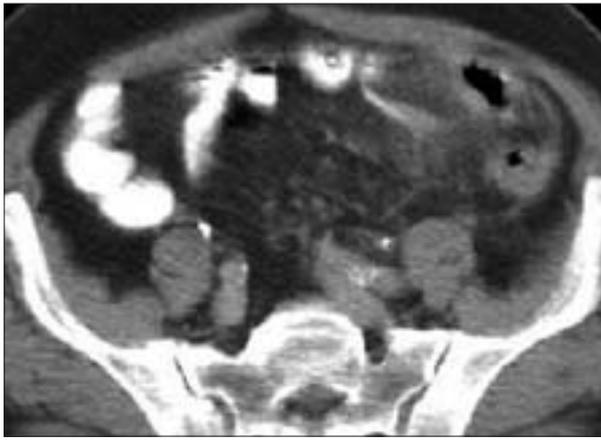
Axial CT image shows increased attenuation of mesocolic fat in a case of epiploic appendagitis. The location of acute epiploic appendagitis is most commonly adjacent to the sigmoid colon, whereas acute omental infarction is typically located in the right lower quadrant and often is mistaken for acute appendicitis.
